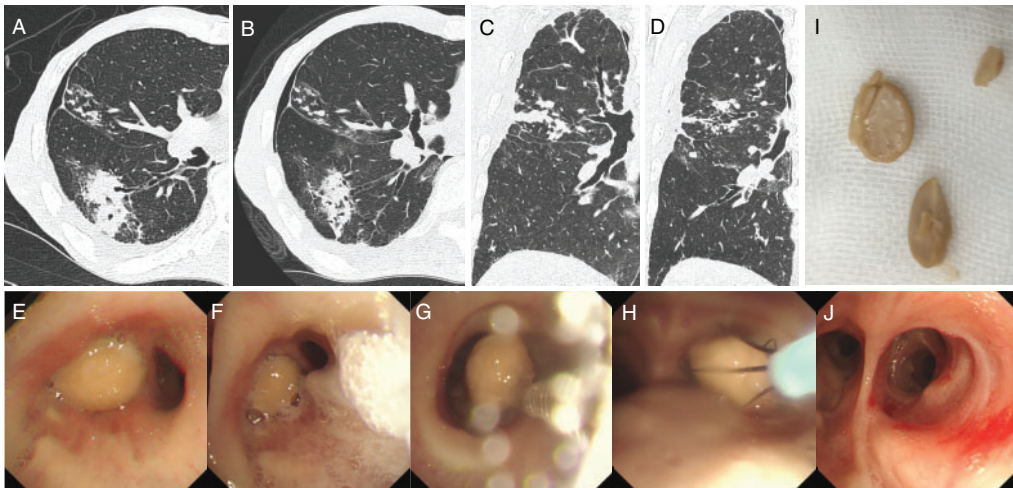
Chest computed tomography (CT) and bronchoscopic findings. (A) Axial and (C) coronal reconstruction CT on admission revealed granular shadows indicative of non-tuberculous mycobacteria in the middle lobe and consolidation attributed to bacterial pneumonia in the right lower lobe. (B) Axial and (D) coronal reconstruction CT demonstrated a new nodular shadow within the right lower lobe bronchus, prompting suspicion of an aspirated boiled soybean. (E) Flexible bronchoscopy revealed an obstructing boiled soybean surrounded by edema and redness. (F) Initially, a brush was used to create a gap, (G) followed by careful extraction using curettage, and (H) basket forceps. (I) The extracted boiled soybean was brittle and fragmented into three pieces. (J) Post-removal examination of the bronchus revealed no residual soybeans.
